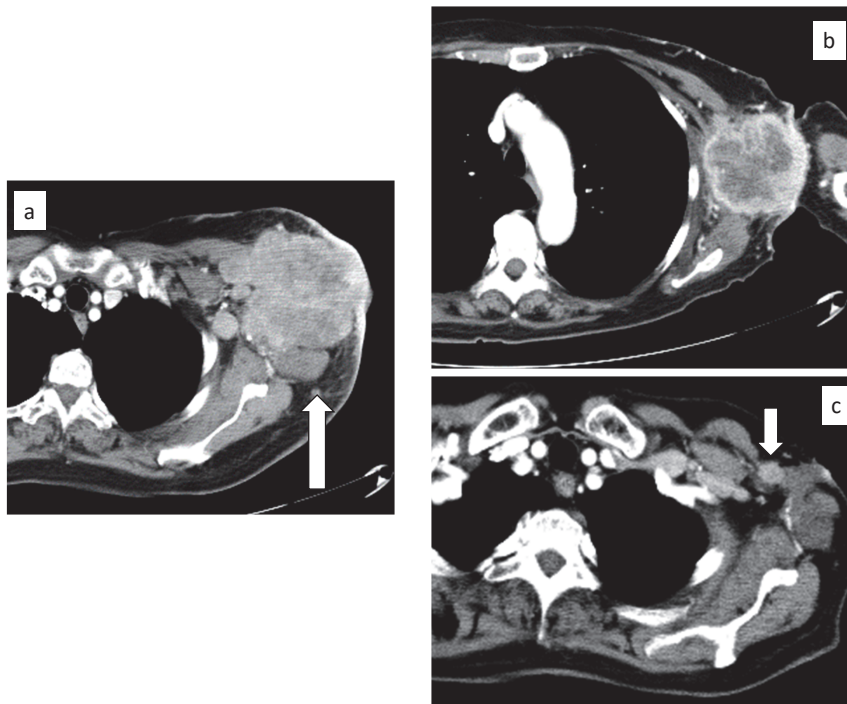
Contrast-enhanced CT findings. (a) A giant axillary mass (before chemotherapy, arrow), (b) Shrunken axillary mass (after EC therapy), (c) A small axillary mass (after docetaxel plus doxorubicin therapy, arrow).
